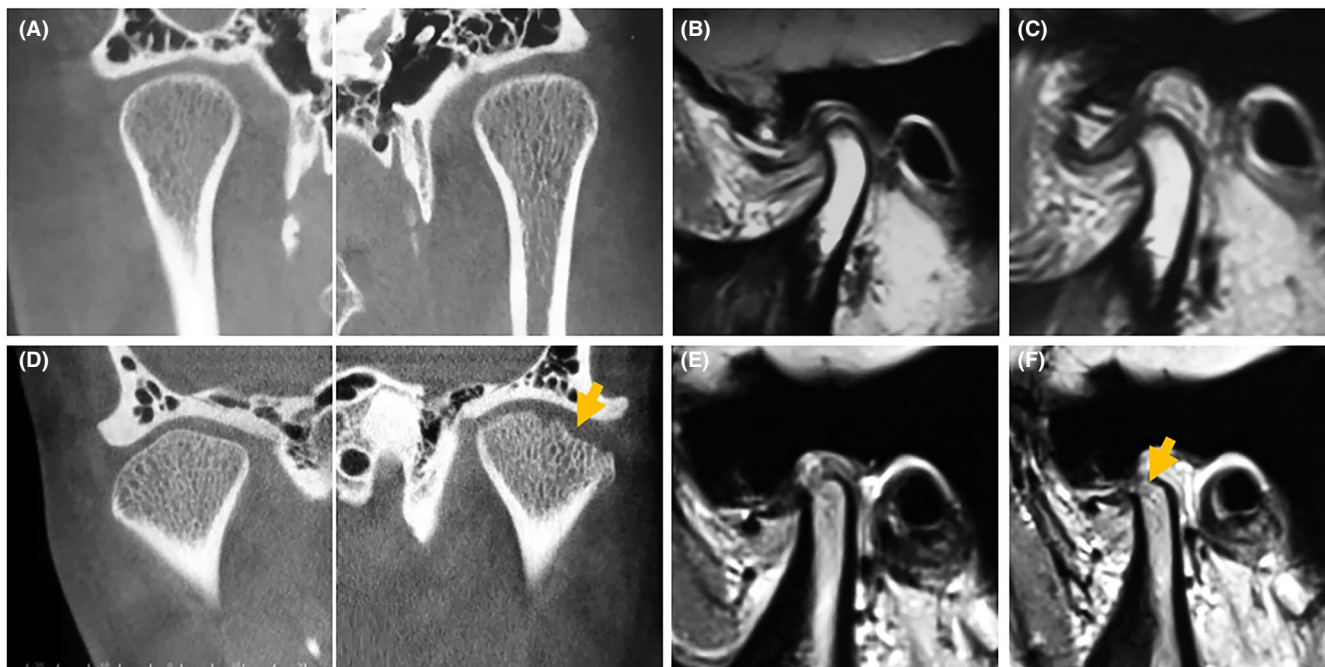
CBCT and MRI images of TMJs with DDw/oR without DJD (A-C) and DDw/oR with early-stage DJD (D-F). (A) Bilateral condyles demonstrating continuity of the articular cortex (without DJD). (B) Displaced disc in closed-mouth position. (C) Displaced disc in open mouth position. (D) Left condyle with early-stage DJD showing subchondral bone destruction (arrowhead). (E) Displaced disc in closed-mouth position. (F) Displaced disc in open mouth position with the absent cortical bone and a focal abnormal signal area in the subarticular region (arrow head) [Colour figure can be viewed at wileyonlinelibrary.com]
